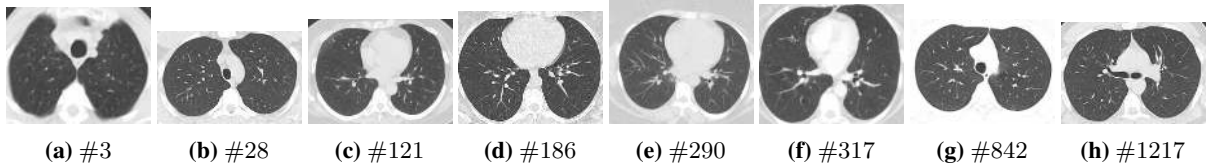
Pneumonia (Non-Covid) infected input lung CT slices [29]
